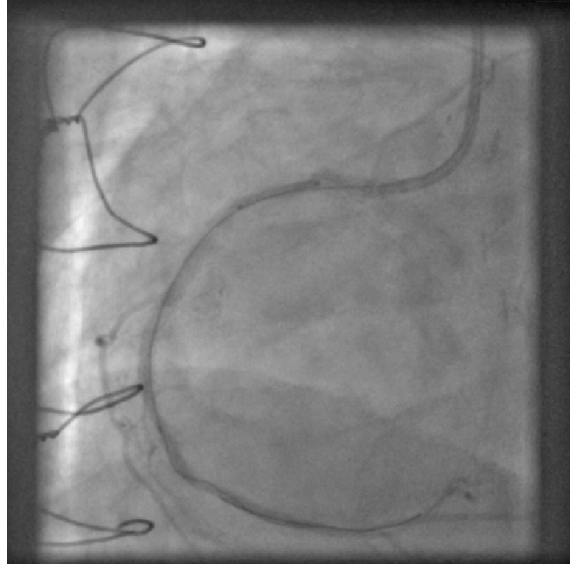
X-ray angiogram of the same coronaries as in Figure 1.15.
